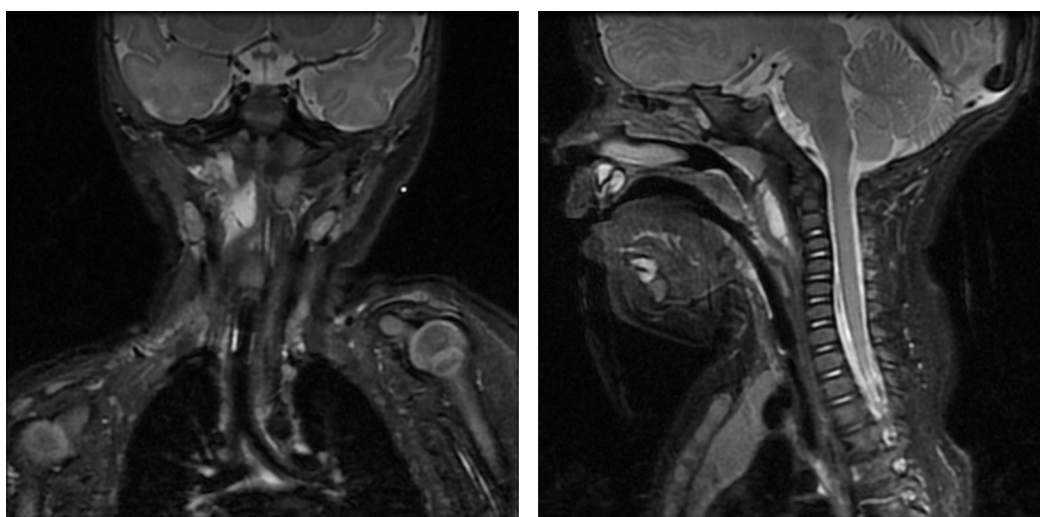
Post-treatment MRI of the neck.
